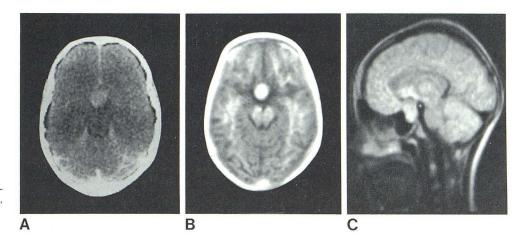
Epidermoid tumor. A, Contrast-enhanced CT scan. B, IR_{1400/400}. C, Sagittal SE_{1080/40}.
